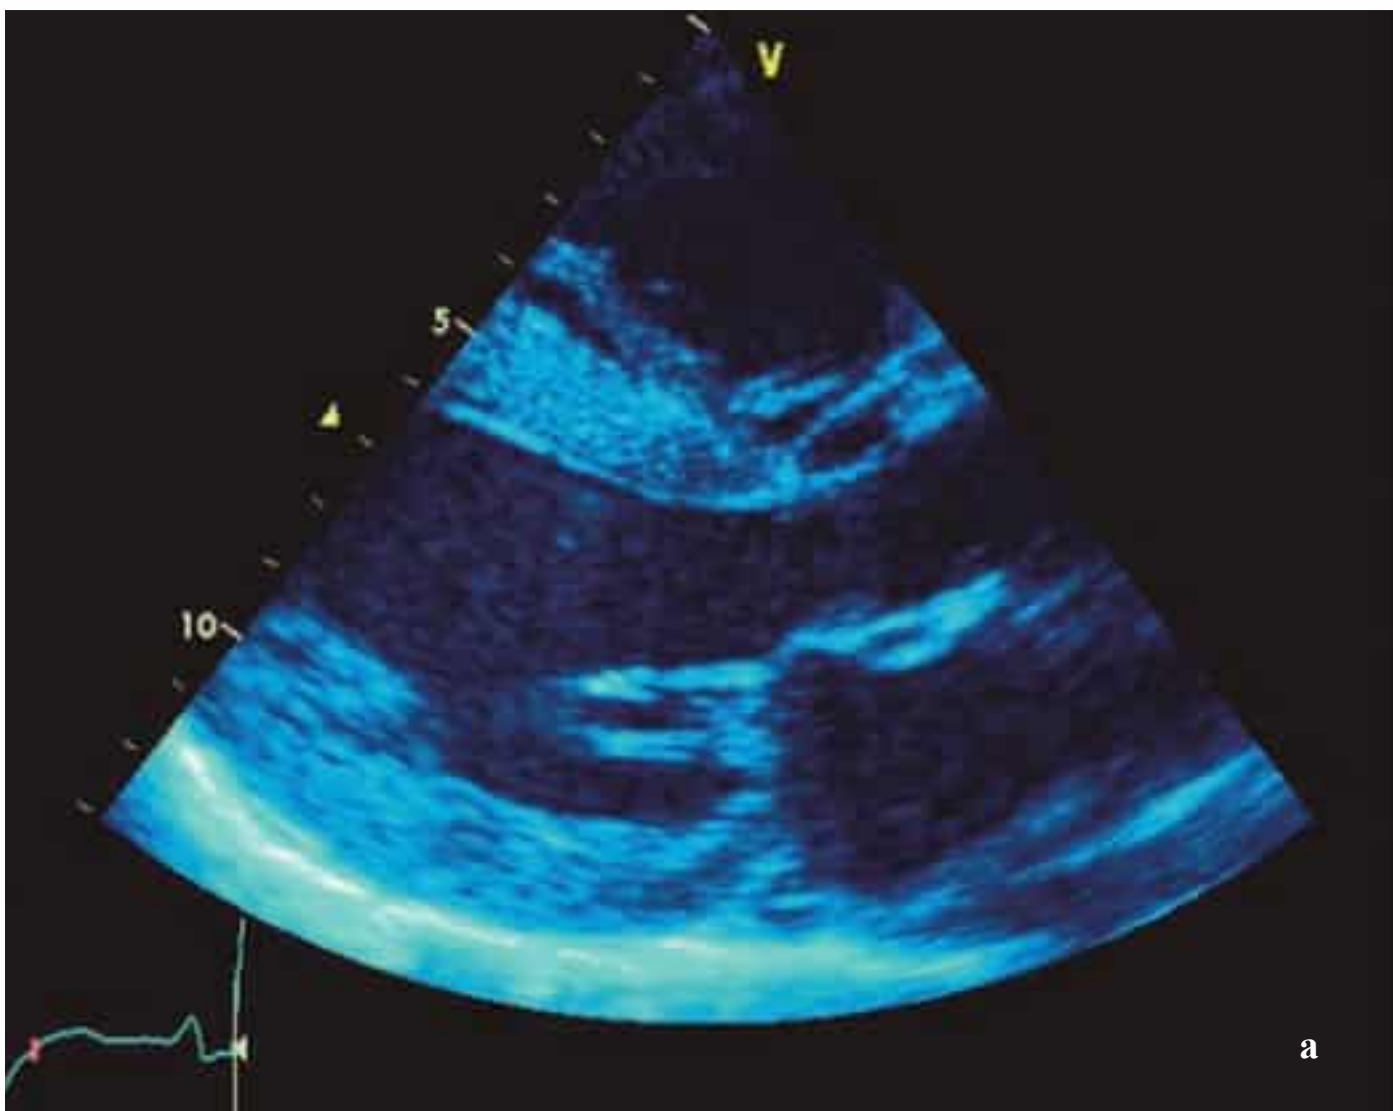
a, b Restrictive cardiomyopathy in a woman with amyloidosis. Transthoracic echocardiography shows left ventricular hypertrophy, thickening of the mitral valve apparatus, and an abnormal myocardial texture.
